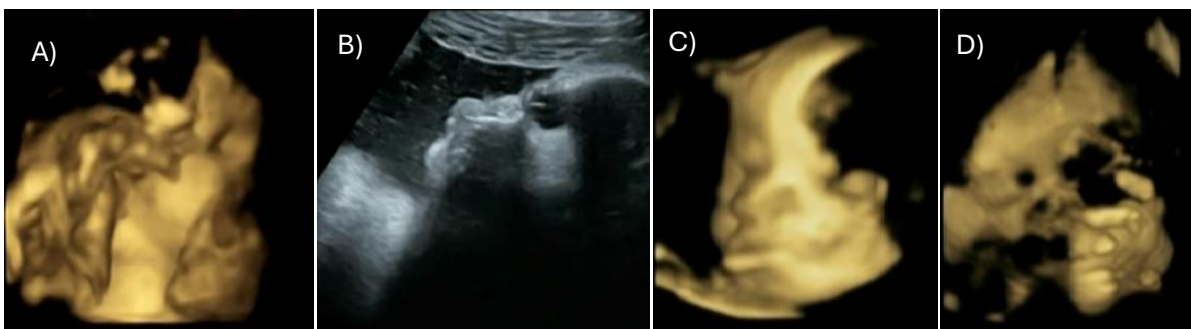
Screenshots exemplifying sections of 4D ultrasound unacceptable for coding. A) Placental obstruction. B) Section of 2D-ultrasound to re-focus on the face. C) Poor image quality due to blurring. D) Poor image quality due to shadowing.
